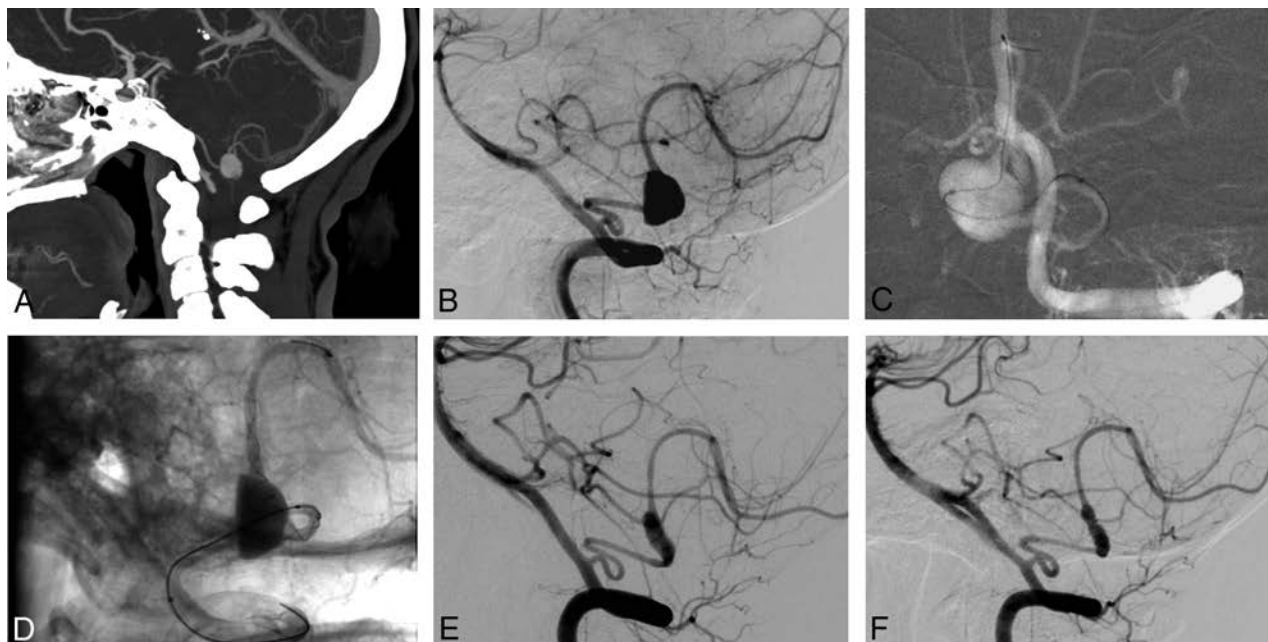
Preprocedural CT and procedural and follow-up angiograms of a 39-year-old female patient with a distal PICA aneurysm. *A*, CT angiography reconstructed on a sagittal projection shows a saccular aneurysm in the PICA. *B*, A preprocedural DSA image depicts a 7-mm saccular aneurysm located in the tonsillomedullary segment of the left PICA. *C*, A roadmap DSA image obtained during the procedure shows the catheterization of the distal PICA for stent placement. This image also demonstrates that the aneurysm has a very complex morphology without a definable neck. *D*, A nonsubtracted angiography image shows the deployment of the stent into the PICA. Please note the compaction and expansion of the stent across the orifice of the aneurysm. *E*, A 12-month follow-up DSA image reveals the reconstruction of the parent artery and no aneurysm filling. *F*, The 24-month follow-up DSA image confirms the stable occlusion of the aneurysm.
